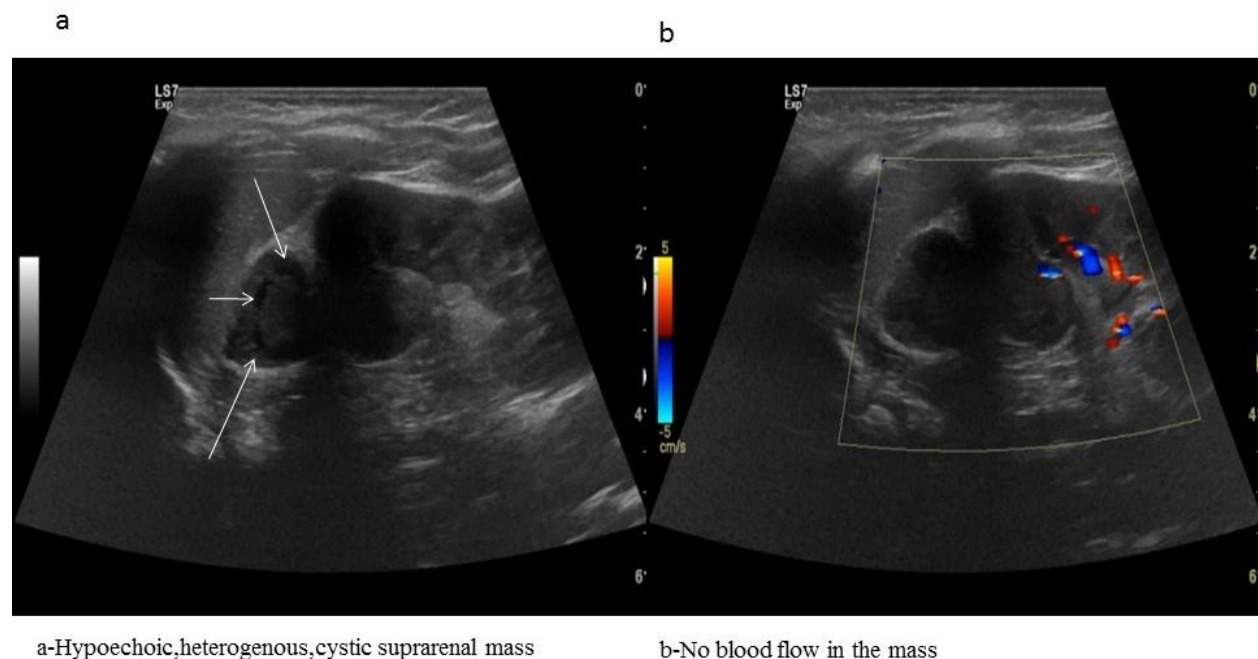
Ultrasonographic images of the mass
